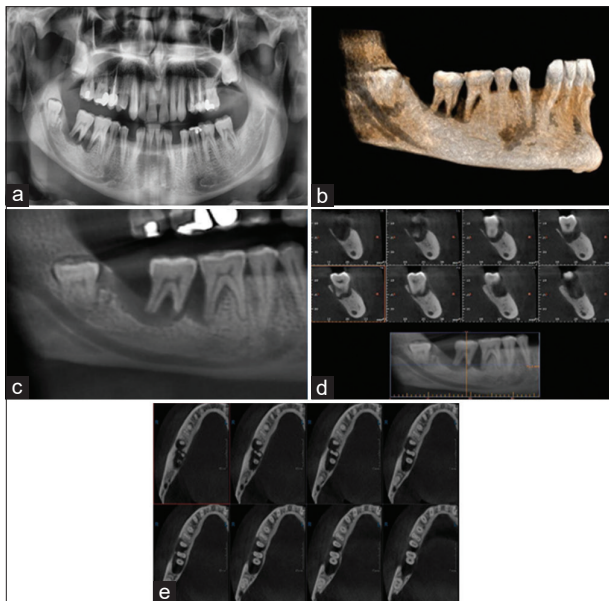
(a) Panoramic X ray demonstrating severe bone loss and radiolucent lesion extending from the distal root of tooth 46 to the wisdom tooth 48 (b) 3D reconstruction (c) Cropped panoramic reconstruction, lower right posterior region. Well-defined low-density periapical image, extending from the distal root of 46 to the ramus. Apical resorption of 47. The teeth seem floating in air. Concerning the tooth 48: According to Pell and Gregory classification: - Depth of insertion: 48 is in a level 3 impaction (fully embedded) -Ramus relationship: class 3 (totally below the angle of the mandible) and finally, for the direction of angulation, we used the winter's classification, in our case, tooth 48 had a vertical angulation. There seems to be a continuity of the low density image mesial to 48 (d) Cross sectional cuts: extension of the lesion - interruption of buccal cortical bone at the level of 47 (e): Series of axial cuts showing the extension of the lesion, interruption of buccal cortical bone and relationship with 48.
